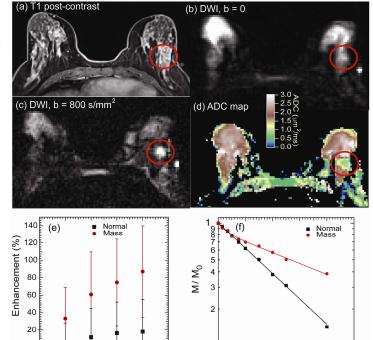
Breast lesion imaging. (a) T1 post-contrast image. (b) DWI unweighted (b=0),(c) DWI b=800 s/mm², (d) ADC. (e) Contrast enhancement and (f) DWI decays for mass and fibroglandular tissue.
